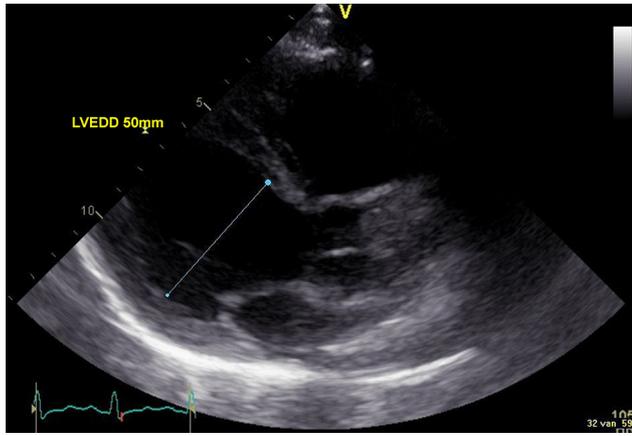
Echocardiogram with an improved heart function 1 year after re-initiation of clozapine. LVEDD, left ventricular end-diastolic dimension.
